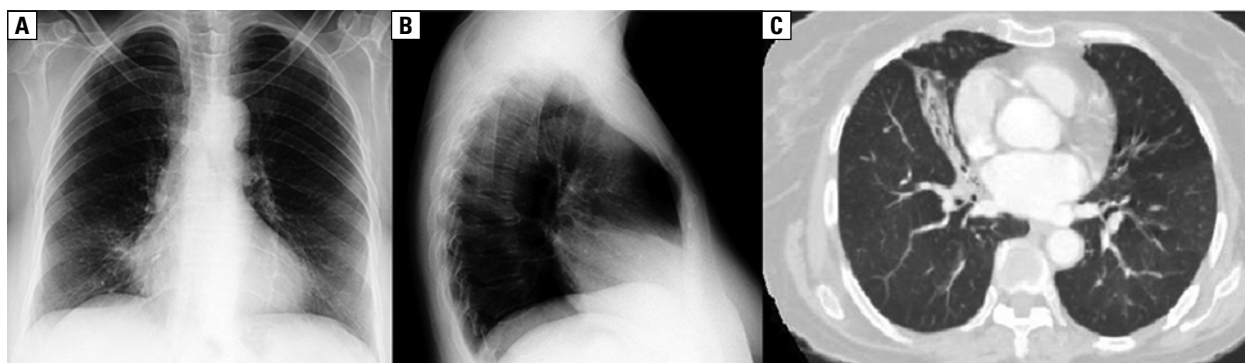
A — chest X-ray postero-anterior view showing ill-defined opacity in the right mid and lower zones abutting the right cardiac border with loss of cardiac silhouette suggestive of right middle lobe syndrome; B — chest X-ray right lateral view showing a wedge-shaped density extending from the hilum anteriorly and inferiorly towards the chest wall, confirming the presence of middle lobe syndrome; C — high-resolution CT of the thorax (lung window) showing a trapezoidal opacity with its base towards the hilum and contiguous with the right cardiac border confirming middle lobe syndrome
